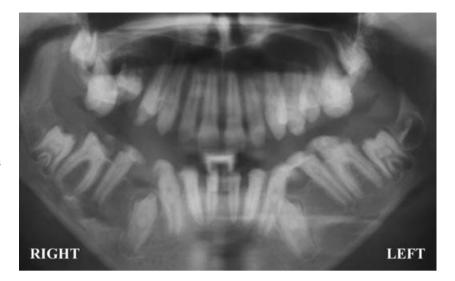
Panoramic radiography of the patient at the age of 10 years, 5 months showing all erupted and unerupted teeth with intrapulpal calcifications. Note the agenesis of the maxillary right second premolar. Well-defined pericoronal radiolucencies were observed around the unerupted permanent mandibular second molars.
